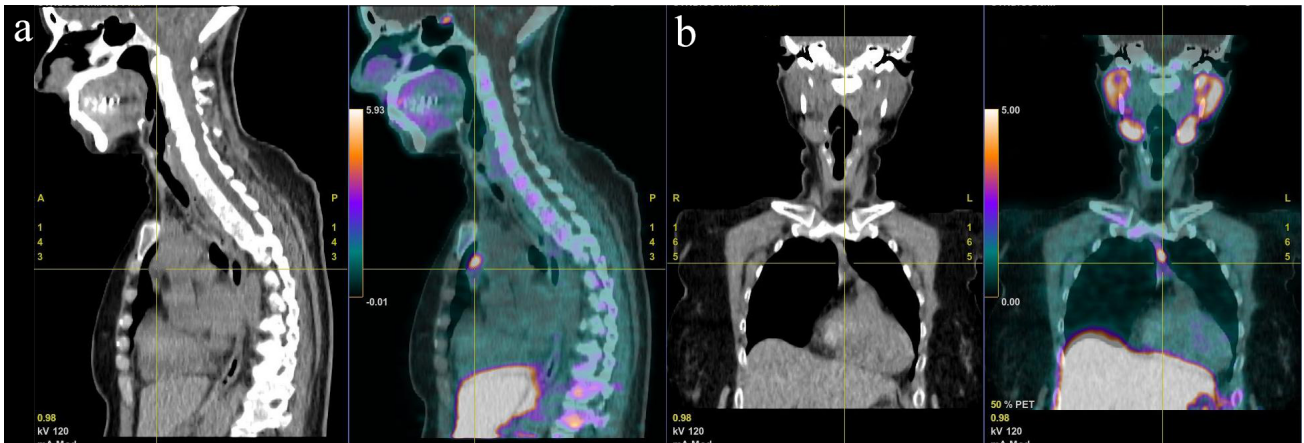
Case 2: Dual-phase imaging with choline PET/CT localizing parathyroid adenoma on the superior mediastinal left area. (a) Sagittal view of a choline PET/CT scan compared with sestamibi radiotracer imaging. (b) Coronal view of a choline PET/CT scan compared with sestamibi radiotracer imaging.
